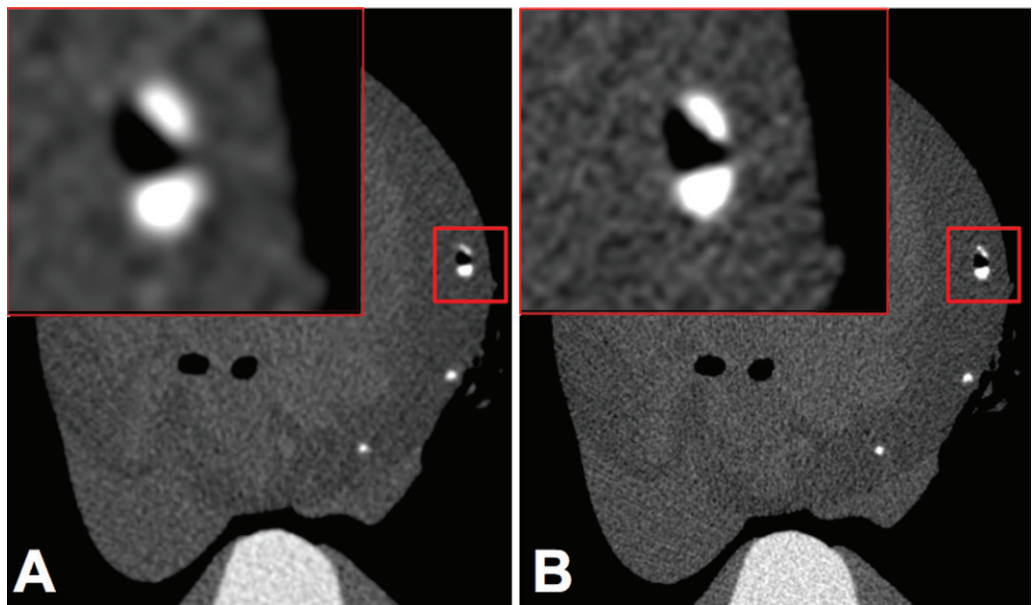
Reduction of the detector element size by half in photon-counting detector (PCD) reduced blooming of calcified plaques in this ex vivo human heart sample. Images were acquired at similar tube voltage, current, and focal spot size. A, PCD CT image acquired at standard resolution (macro mode) and, B, high-spatial-resolution (sharp mode) image obtained with prototype scanner (Siemens Healthineers, Forchheim, Germany). (Images are from National Institutes of Health [68].)
